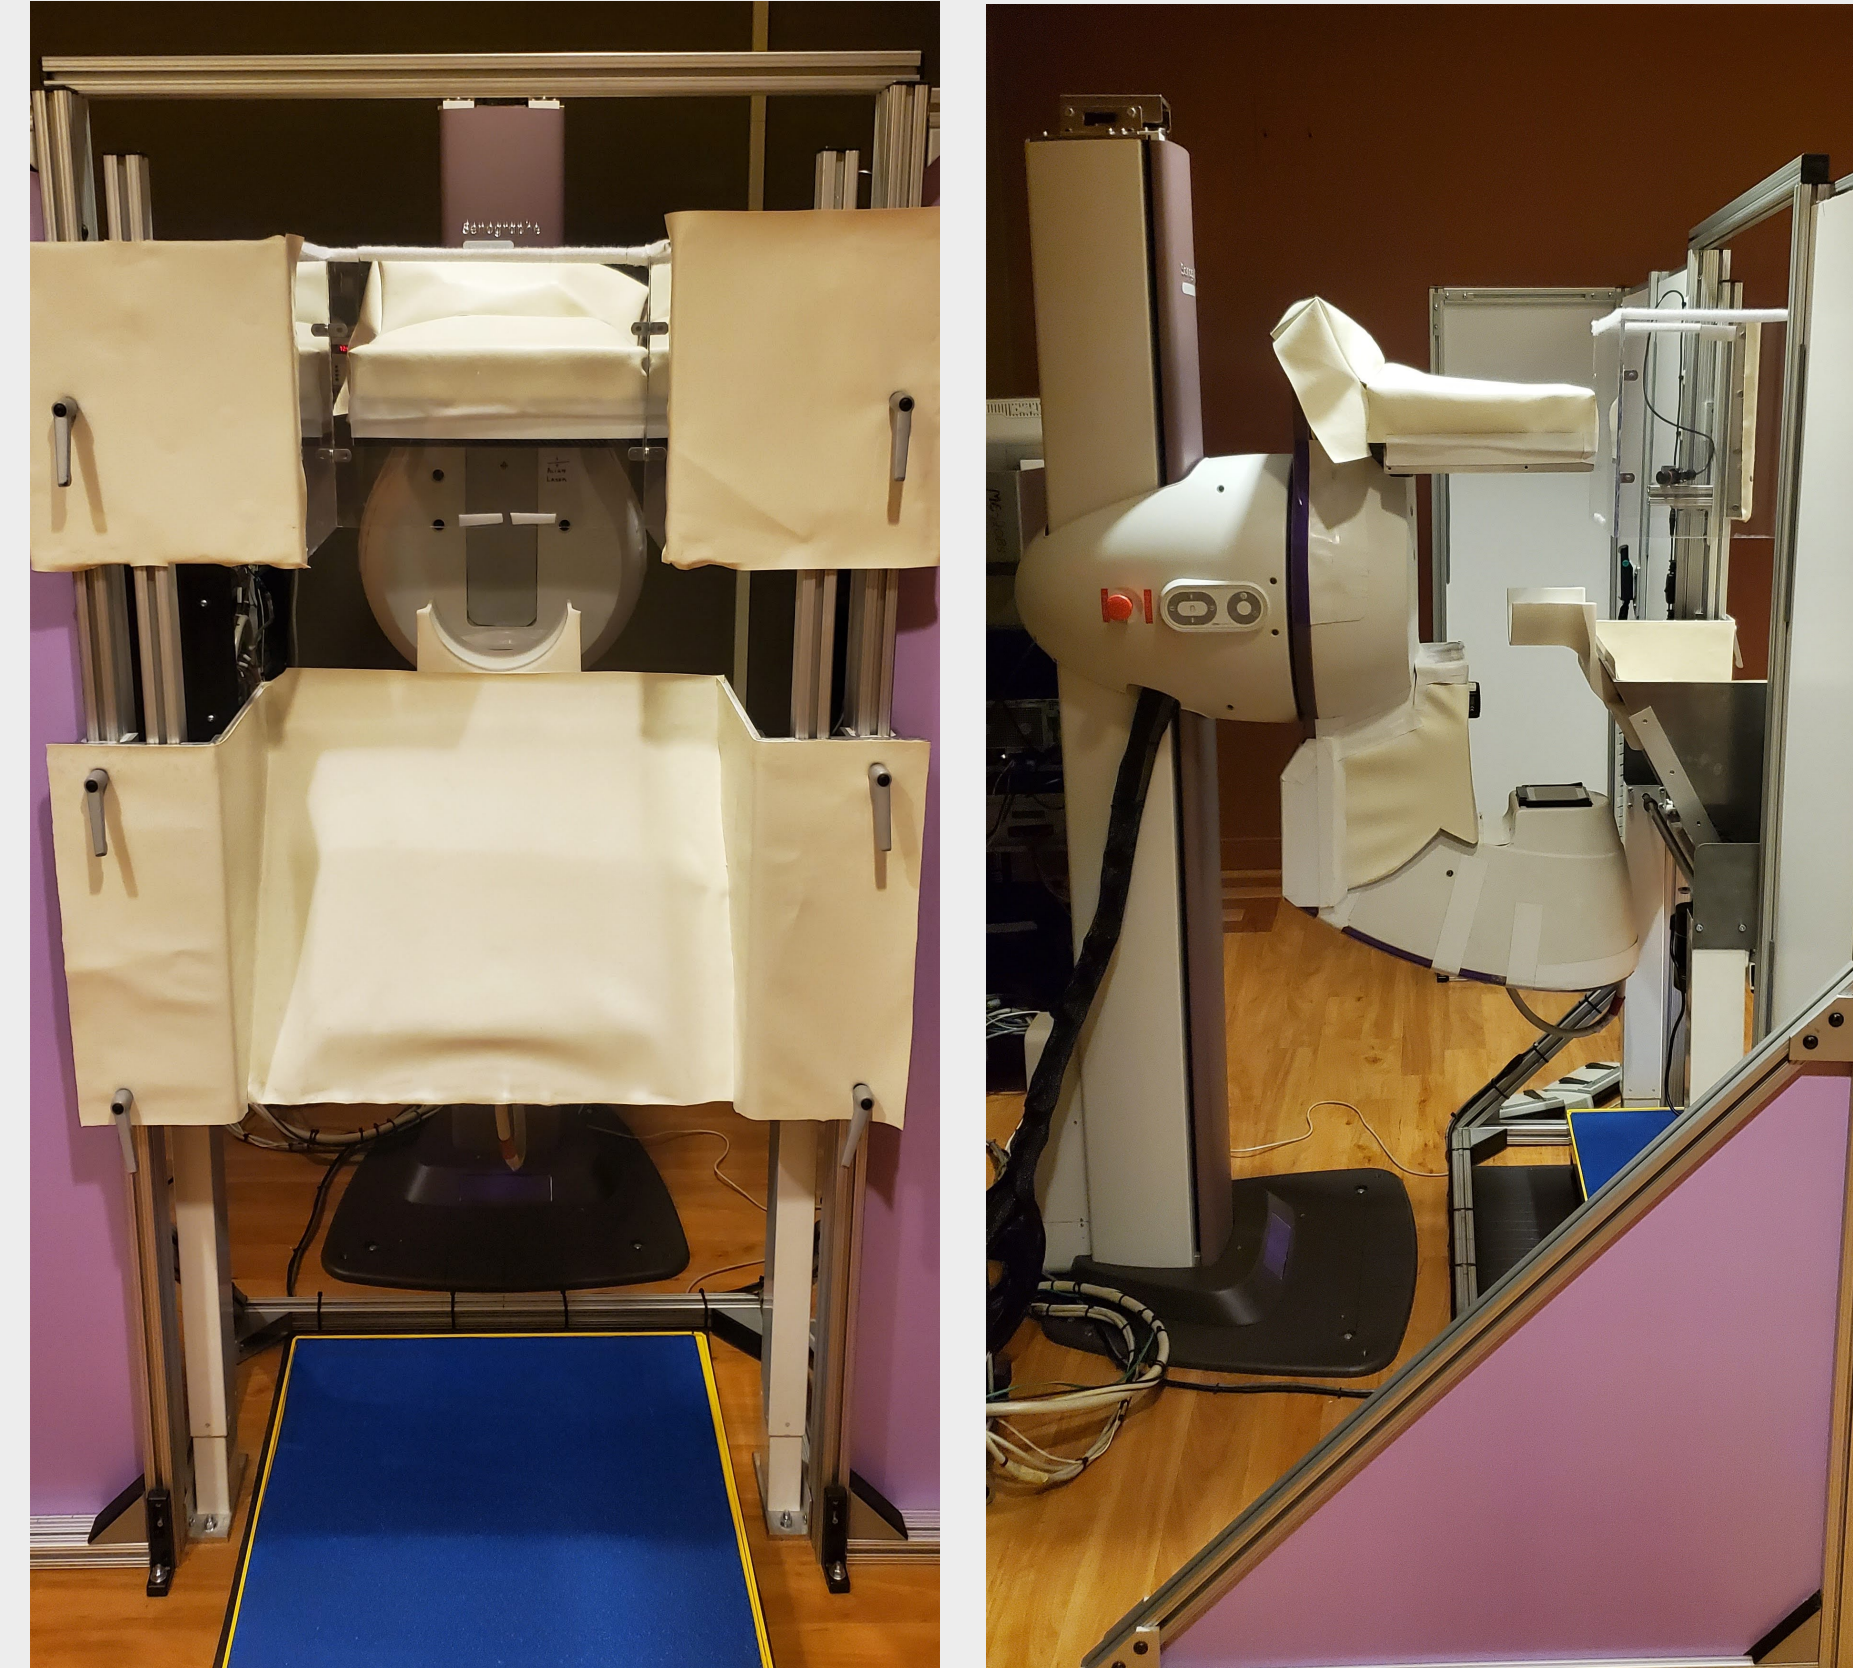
Pictures of the upright cone-beam breast CT system. Left: front (patient) view; Right: side view.
